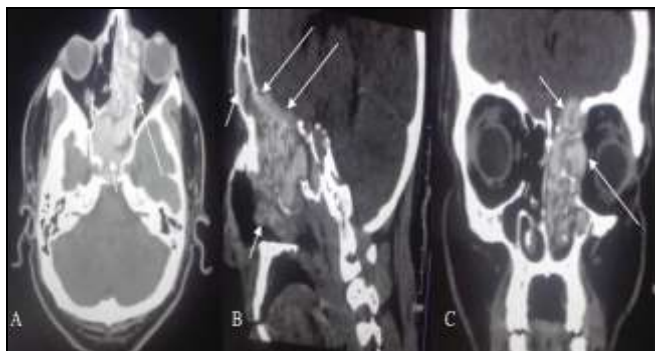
Non-Contrast CT Paranasal Sinuses
